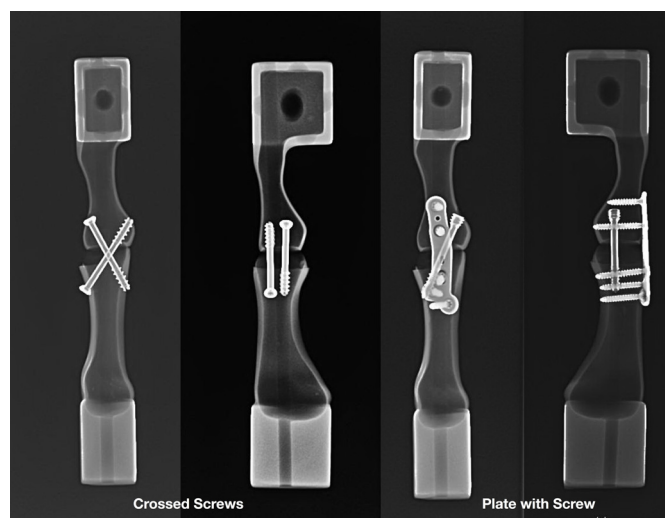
Xrays of Crossed Screw and Plate and Screw fixation methods.
